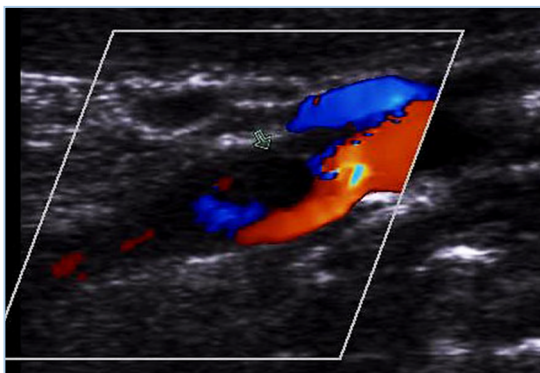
Type I-Uniformly echolucent plaque. Longitudinal plane. Color Doppler.
